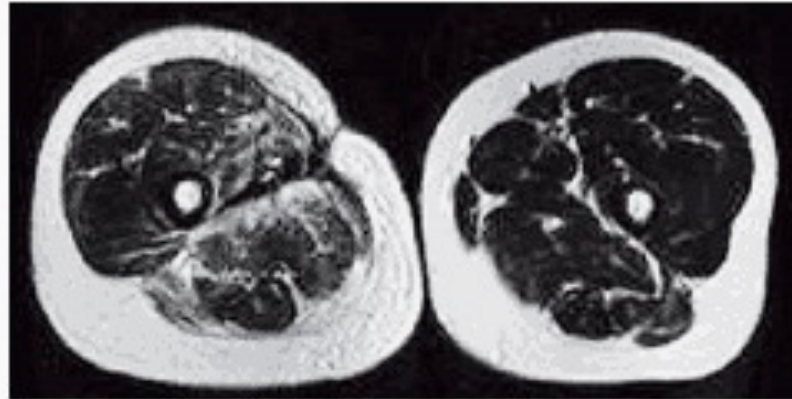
MRI von einem Mann (32 Jahre) der Oberschenkelmuskulatur (Bild von Prof. Dr. Chris Boesch, MR-Zentrum, Inselspital Bern, Schweiz)
